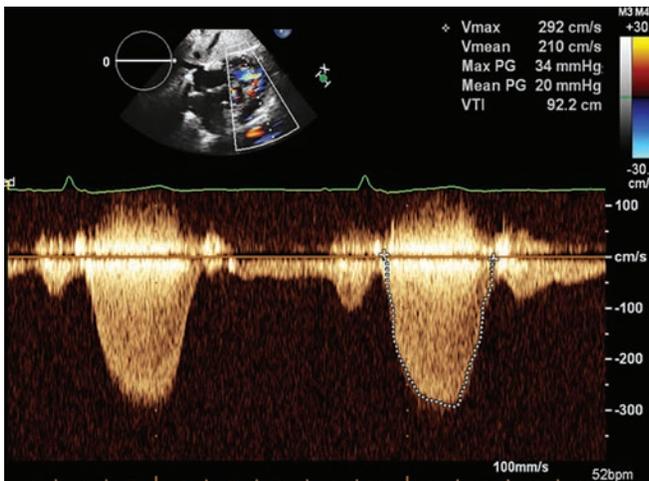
Continuous wave Doppler signal interrogating the right ventricular outflow tract.
